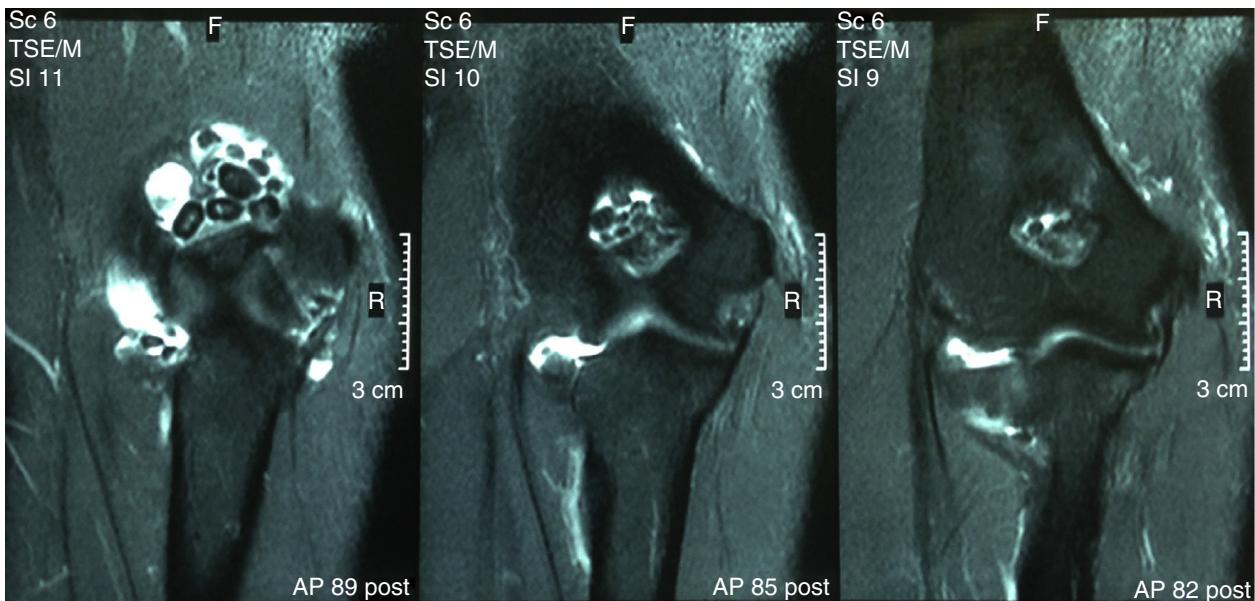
T2-weighted coronal magnetic resonance imaging showing many free bodies in the fossa of the olecranon and in the lateral compartment, along with a chondral lesion in the capitellum.
